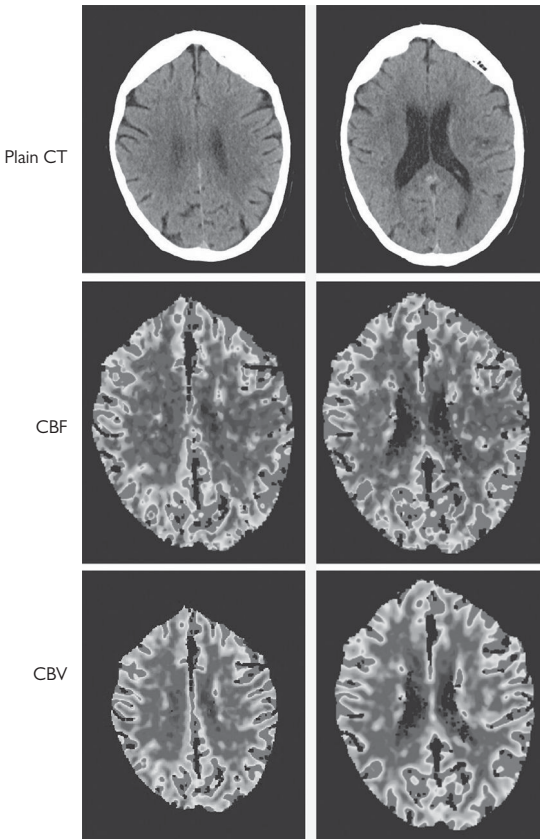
Another patient in whom CT perfusion imaging suggests penumbral tissue. This patient with a left carotid stenosis presented with dysphasia. The CT perfusion showed a CBF deficit in the left frontal region but on CBV the blood volume was preserved consistent with salvageable tissue. The patient responded well to IV thrombolysis. © Hugh Markus.
